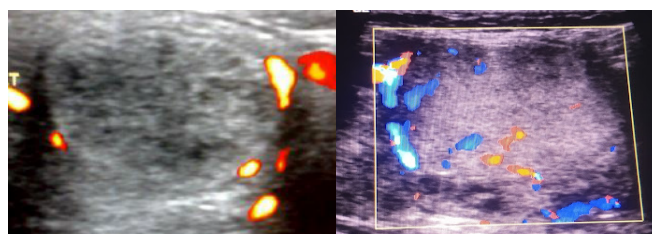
(A, B) Color flow pattern in color doppler ultrasound – Figure A shows peripheral or a perinodular pattern of color flow in a pathologically proven follicular adenoma. Mixed central and peripheral color flow in an another benign colloid nodule (B)
